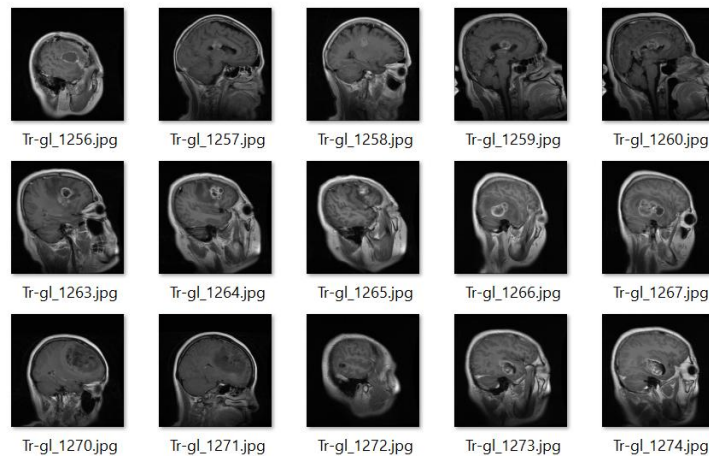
Brain Tumor MRI Dataset for Classification
